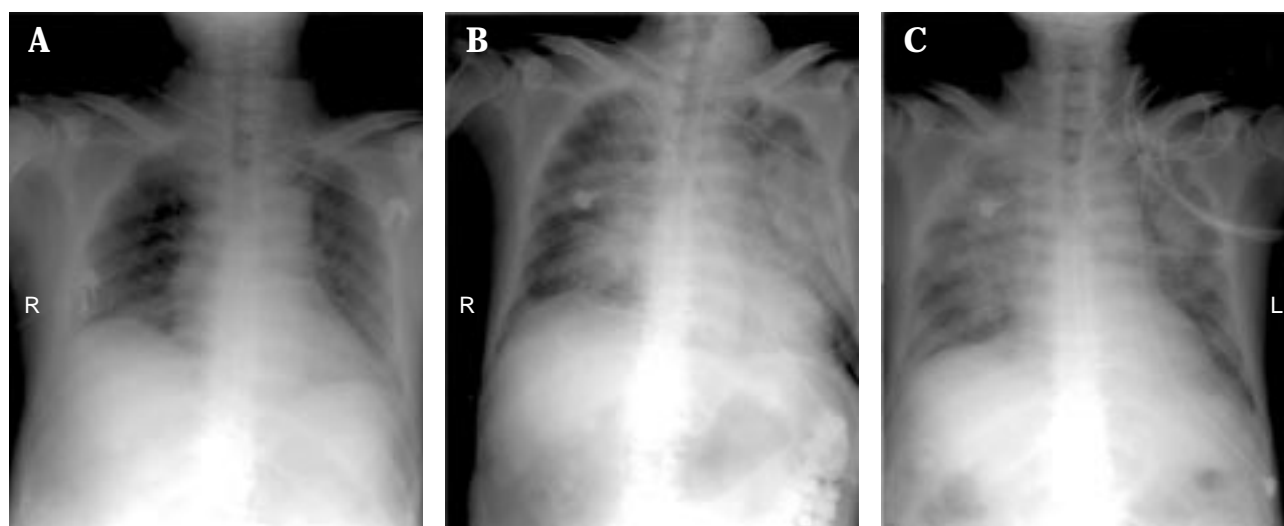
Chest roentgenograms: (A) in the emergency room, showing mild cardiomegaly with pulmonary congestion; (B) on the 3rd hospital day, showing diffuse bilateral pulmonary infiltration with unchanged cardiac silhouette, clear costophrenic angle, no Kerley line, and no thickening of minor fissure; (C) on the 13th hospital day, showing partial resolution of diffuse bilateral pulmonary infiltration.
